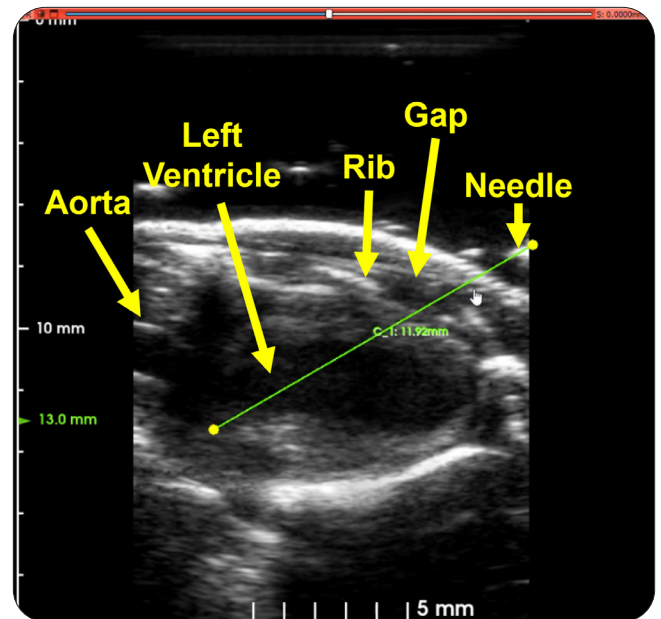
Example ultrasound view of the left ventricle and surrounding features.
